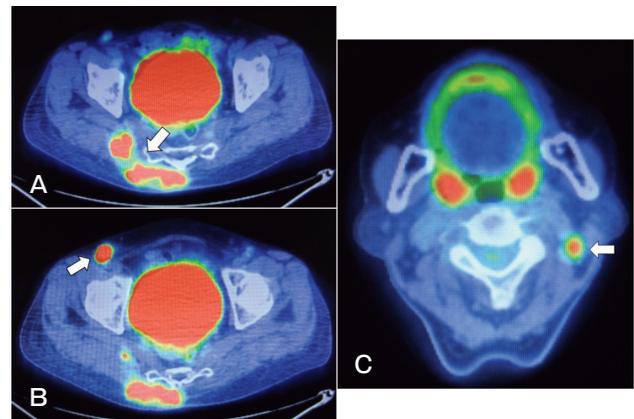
Positron-emission tomography (PET)/computed tomography (CT) with axial views. PET-CT images showed ¹⁸F-FDG uptake in the buttock tumor (A) as well as in the lymph nodes of the right groin (B) and left neck (C), as indicated by the white arrows.
